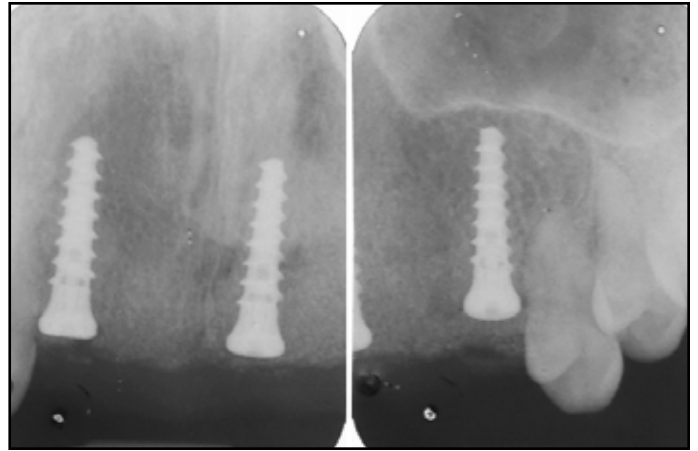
A postoperative periapical radiograph.
